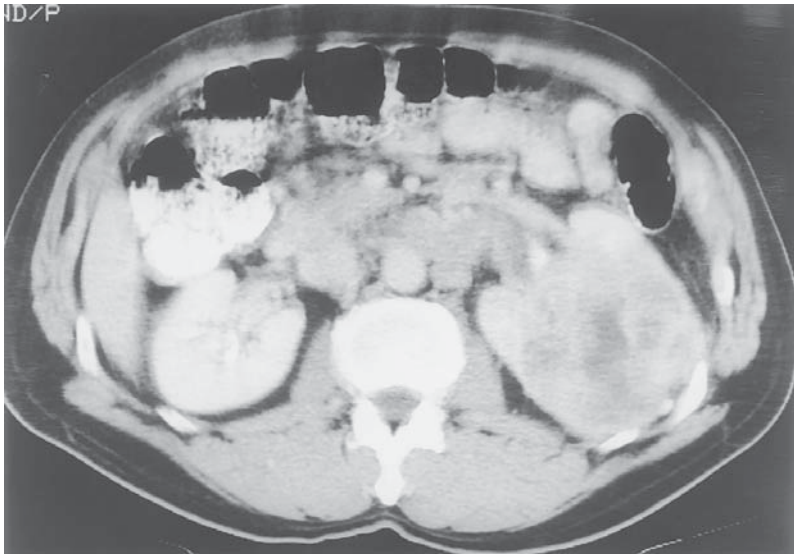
CT scan of enlarged paraaortic lymph nodes proved by lymphadenectomy to be free of tumor.
